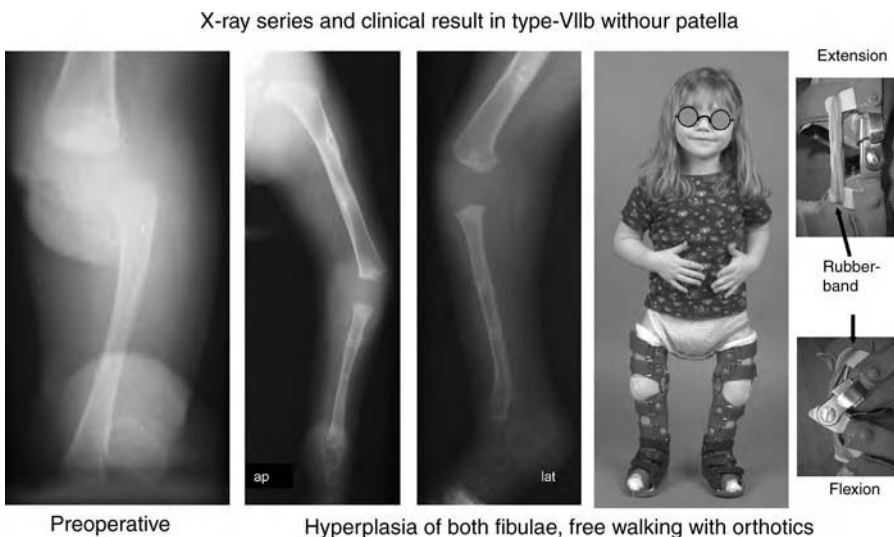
X-ray series shows the hypertrophy of the fibular head stabilized after an anterior cruciate ligament plasty. The six-year-old girl is able to walk and run with the use of orthotic devices on both similarly affected legs three years after surgery. The function of the absent quadriceps muscle is compensated by rubber bands that allows active flexion and gives passive extension. The score of the legs are characterized each by coll/fell (+)/paIII/tiVIIb (+)/fil/pell, (=7 points). This is type VIIb class 5 (Tables 1 and 2).
